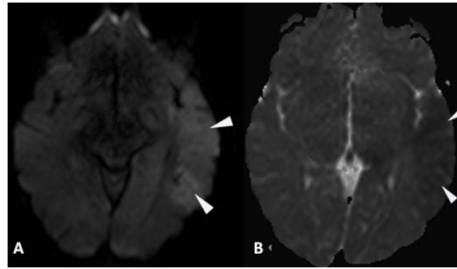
3. The decrease of diffusion because of cytotoxic oedema in diffusion weighted imaging (DWI) (A-B) (arrowheads).
